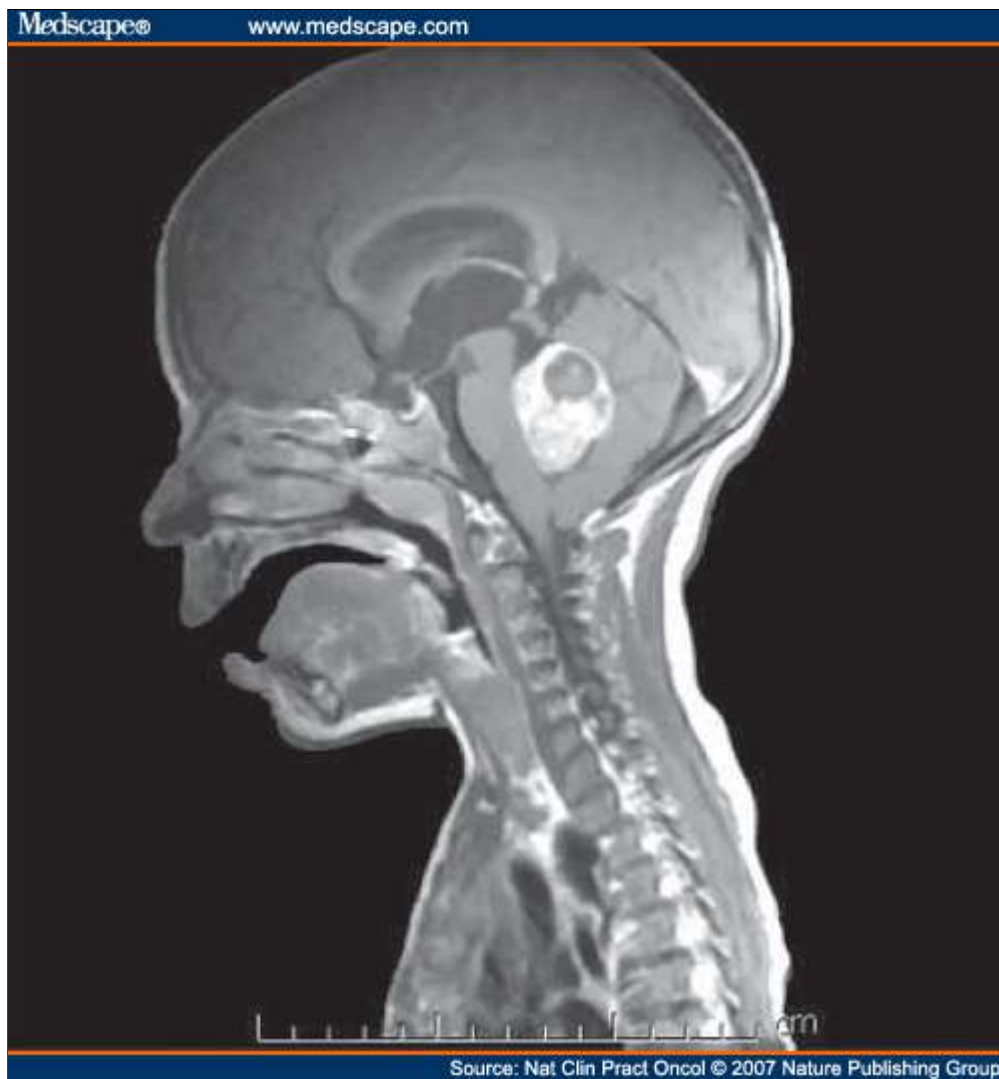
Post-gadolinium MRI of a 4-year-old with medulloblastoma presenting with morning vomiting and ataxia. Note the well-defined enhancing mass obliterating the fourth ventricle.
